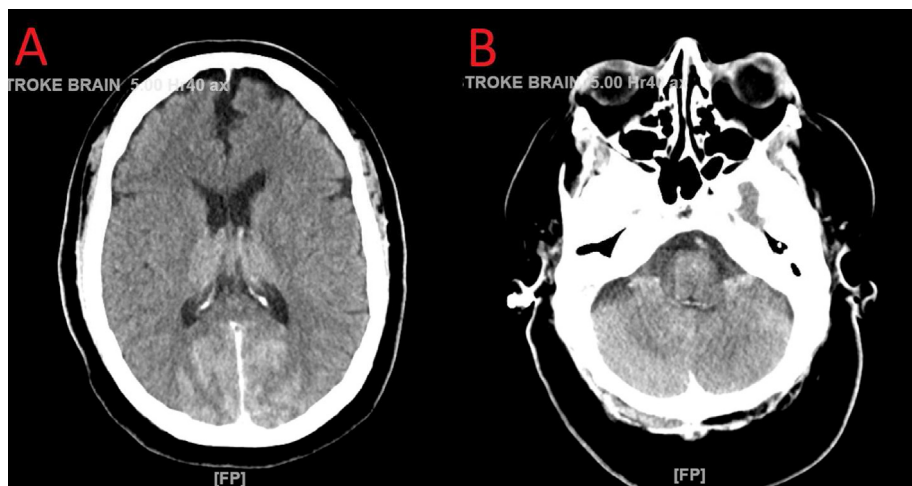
CT scan of the head without contrast immediately after the procedure. A: Residual contrast from cardiac catheterization noted in bilateral occipital lobes. B: Similar residual contrast noted in bilateral cerebellar lobes.
